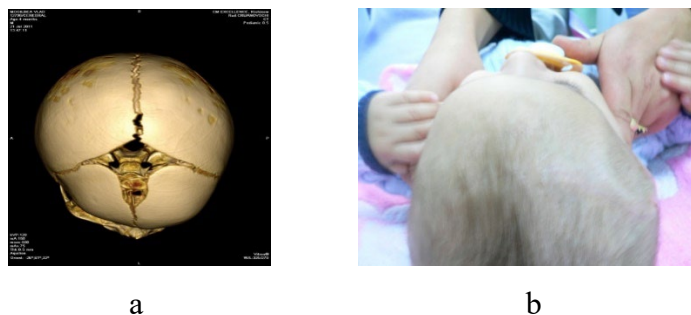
Anterior plagiocephaly: a) CT image; b) superior examination image, synostosis metopic suture: trigonocephaly
